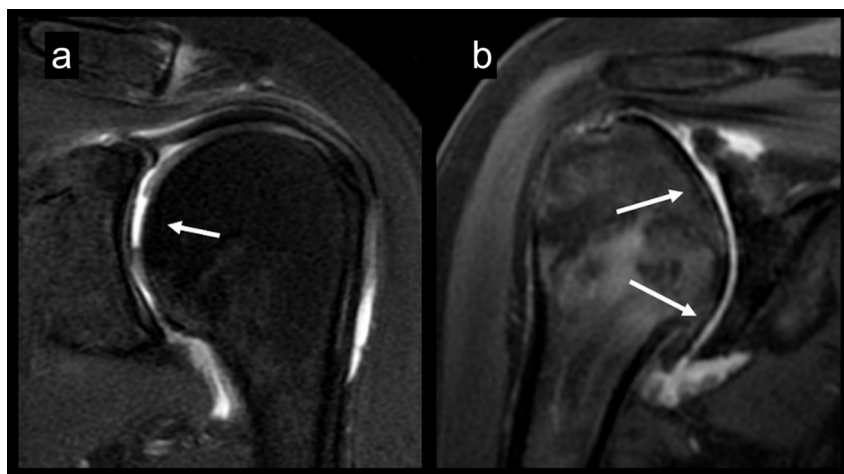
MRI findings of focal versus diffuse glenohumeral chondral lesions. (A) Focal chondral lesion (arrow): typically seen in younger, physically active patients with acute-onset shoulder pain. These lesions are less common and often associated with trauma, joint instability, or mechanical overload. (B) Diffuse chondral lesion (arrows): commonly found in older patients with chronic symptoms, representing glenohumeral osteoarthritis.
